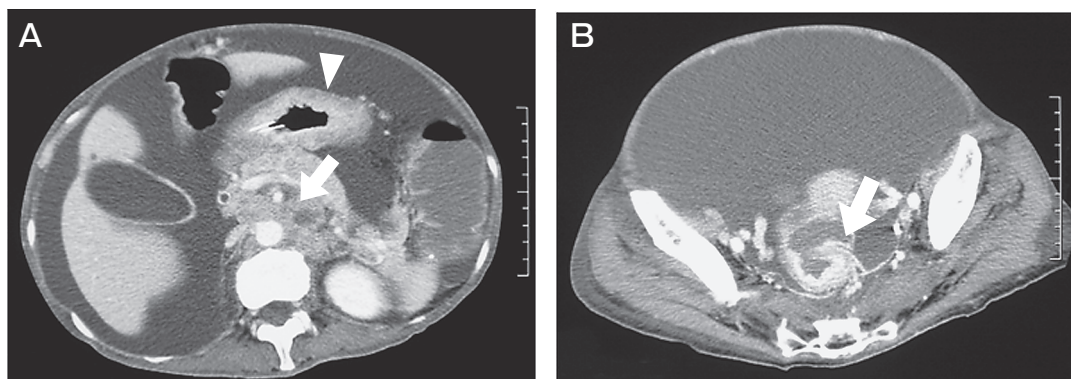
Abdominal CT scan (before chemotherapy). A, Thickness of the stomach wall (arrowhead), paraaortic lymph node adenopathy (arrow); B, An large amount of ascites and rectal stricture (arrow).
